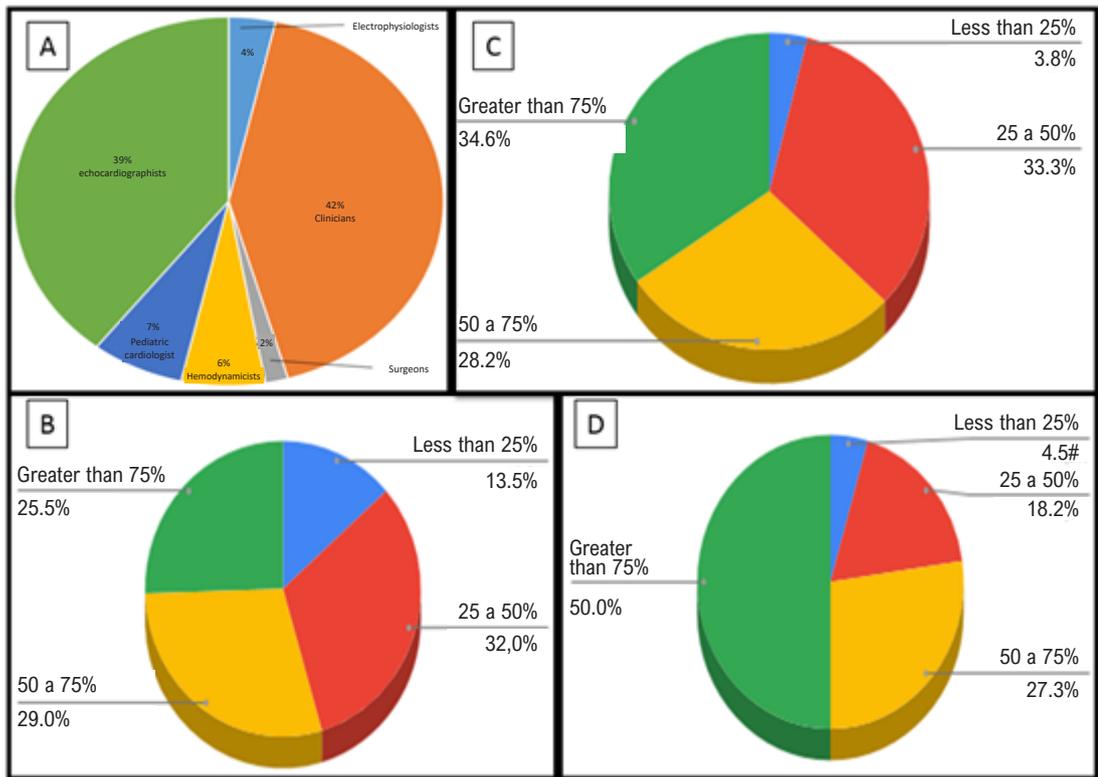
Distribution of cardiologists participating in the study by subspecialties (A) and percentages of professionals that reported a reduction in echocardiographic procedures (B); hemodynamic procedures (C) and cardiac surgeries (D).
